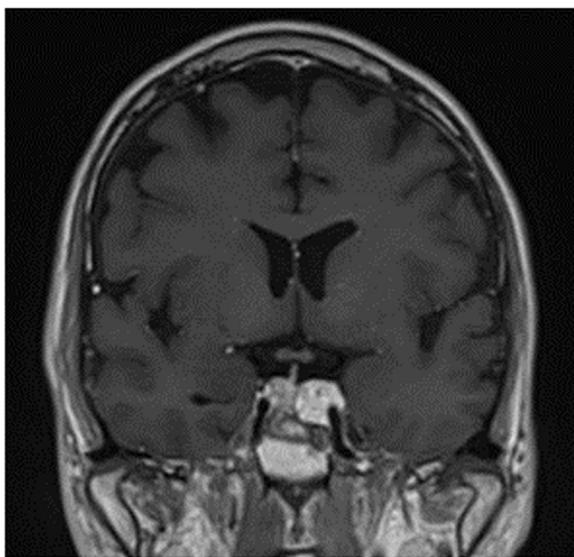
Postradiosurgical coronal T1-weighted magnetic resonance (MR) presenting haemangioma localised in the left cavernous sinus and sella turcica. Stable size of the tumour is confirmed six years after the treatment.
